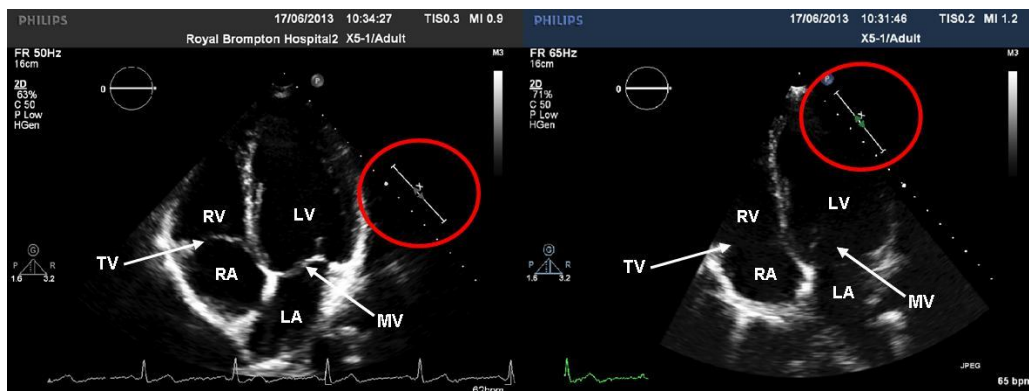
Apical 4-chamber views showing the effect of changing the focus position on image quality. In the image on the left, the focus is mid-depth (circled in red), and the mitral and tricuspid valve leaflets are seen clearly. In the image on the right the focus has been shifted (circled in red) towards the apex of the heart. The mitral and tricuspid valve leaflets are no longer visible.
